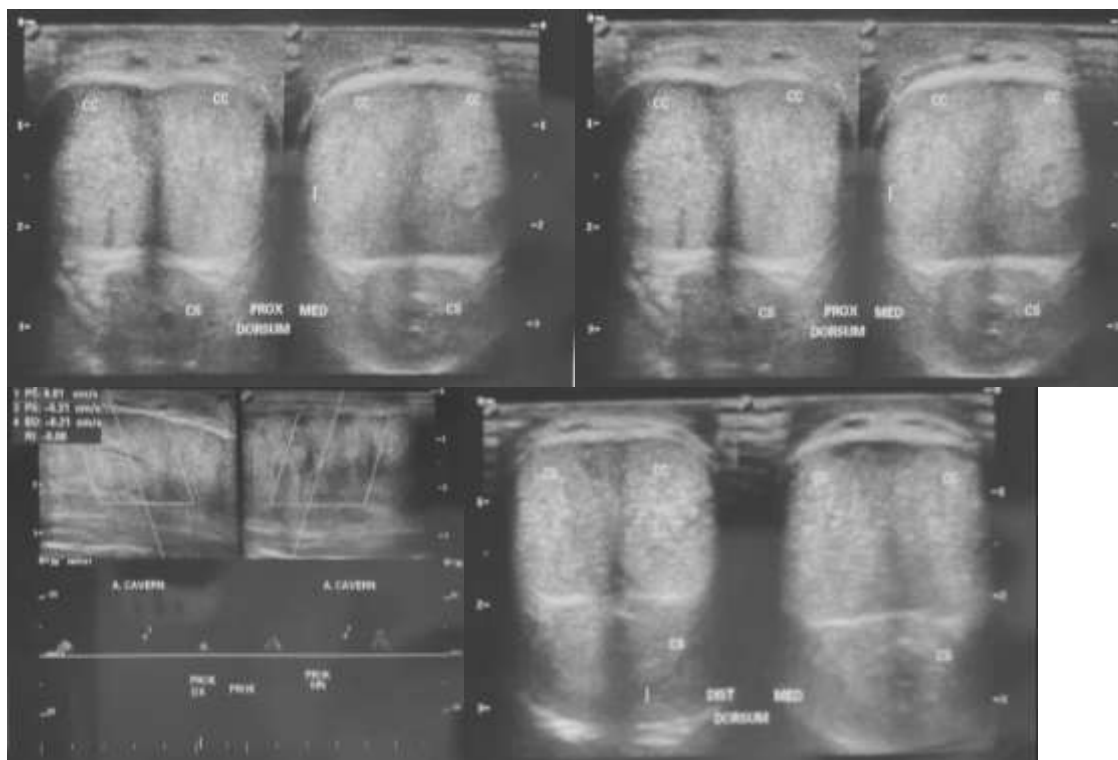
Penile Ultrasonography.
